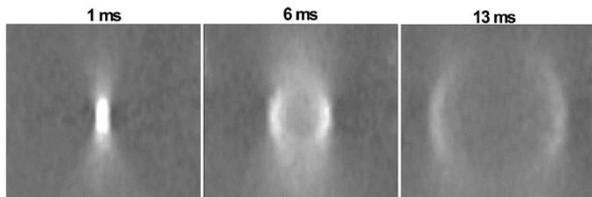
Shear wave induced by an ultrasound beam focused in the center of the image (from ref [8])
